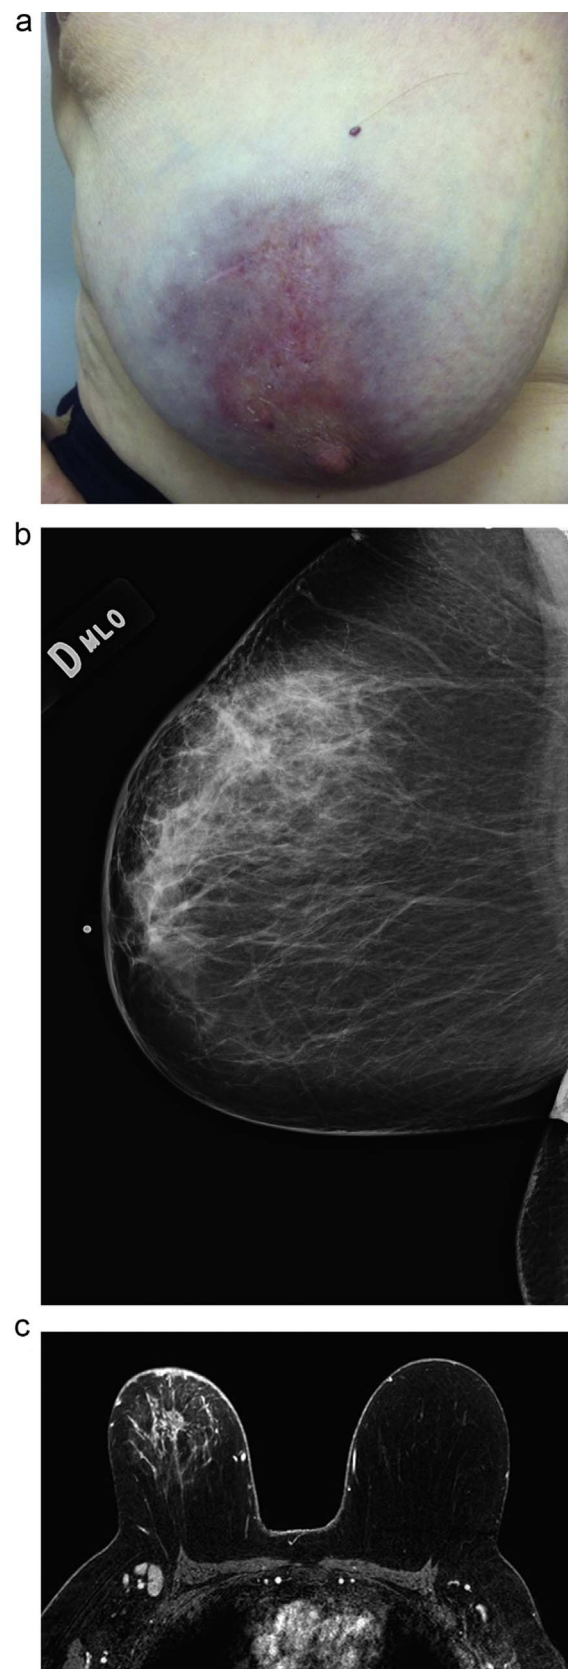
Same patient as Figure 1, six months later. A. The skin is erythematous with a bluish discoloration and desquamation. Note scar from recent open biopsy in the upper quadrant. B. Right MLO view confirms progression of both skin and trabecular thickening as well as progressive asymmetry in the superior breast. C. Axial delayed post-contrast T1-weighted MRI shows skin thickening of the upper right breast, along with mass enhancement in the central breast and an enlarged ipsilateral lymph node.
